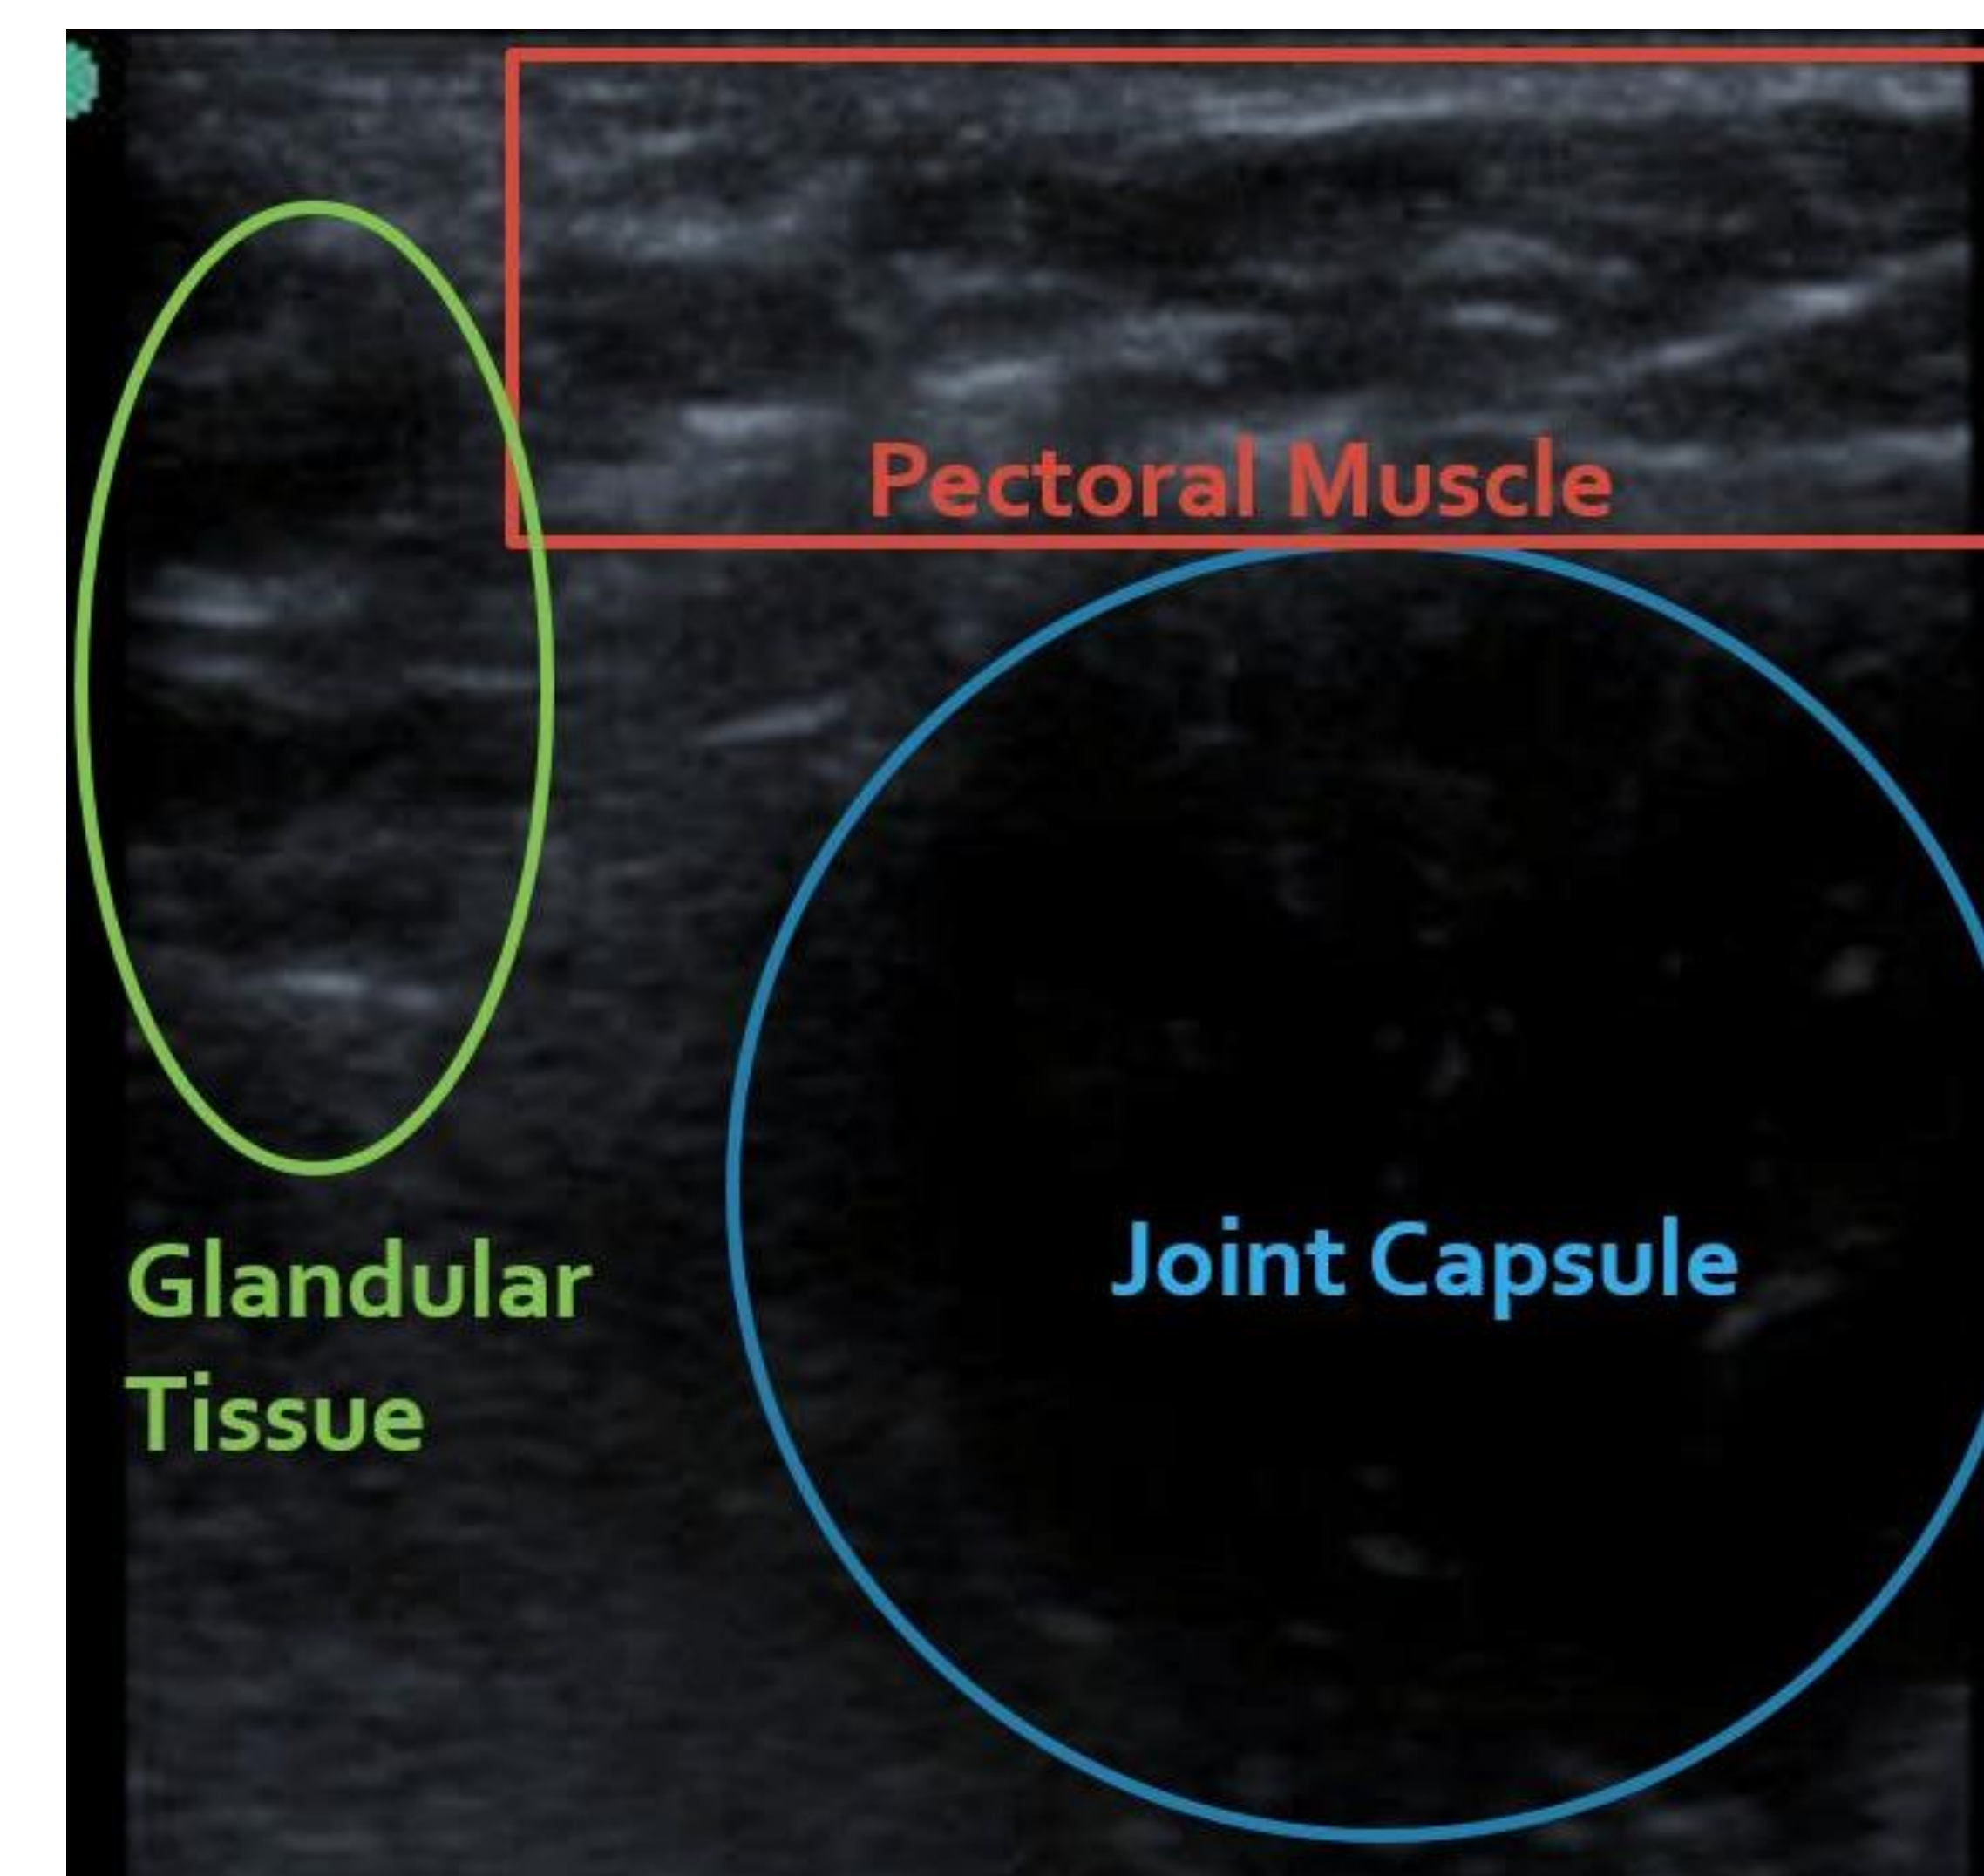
Ultrasound image with identification
